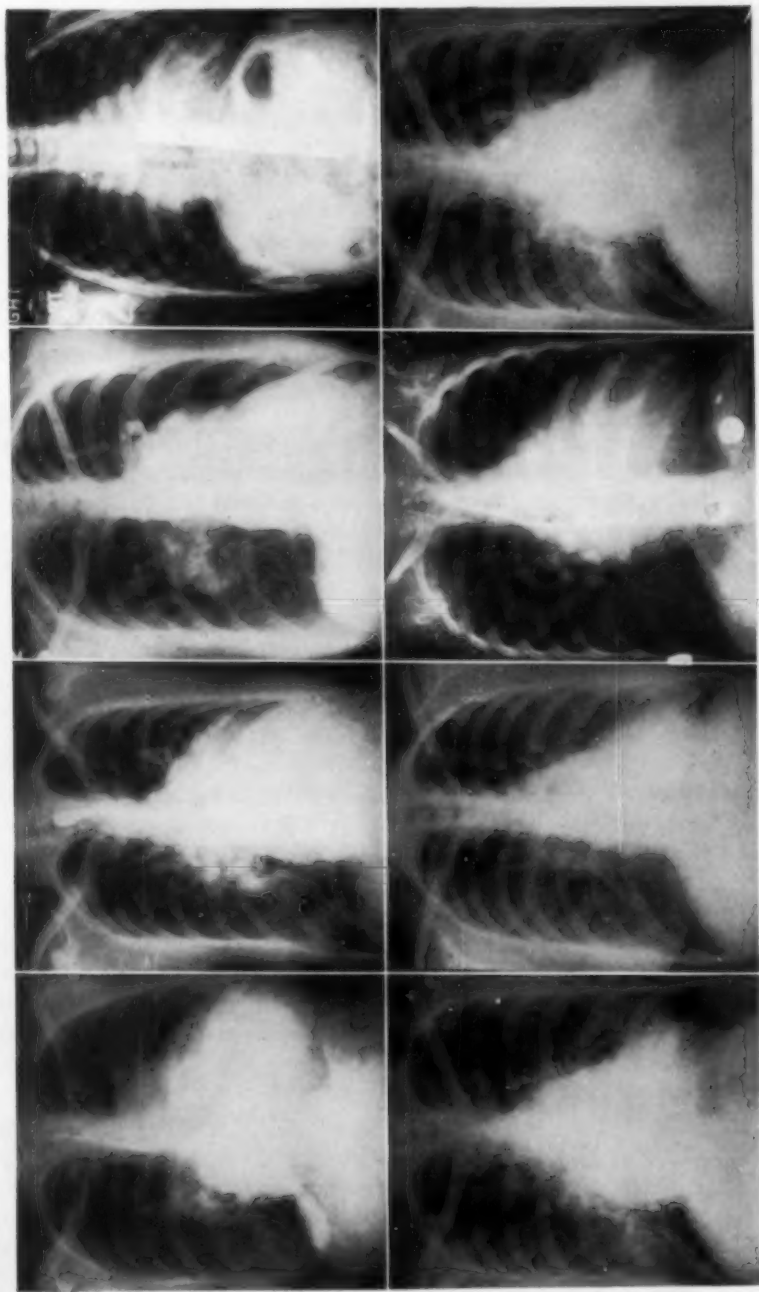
Atrial septal defect. Representative postero-anterior roentgenograms.
